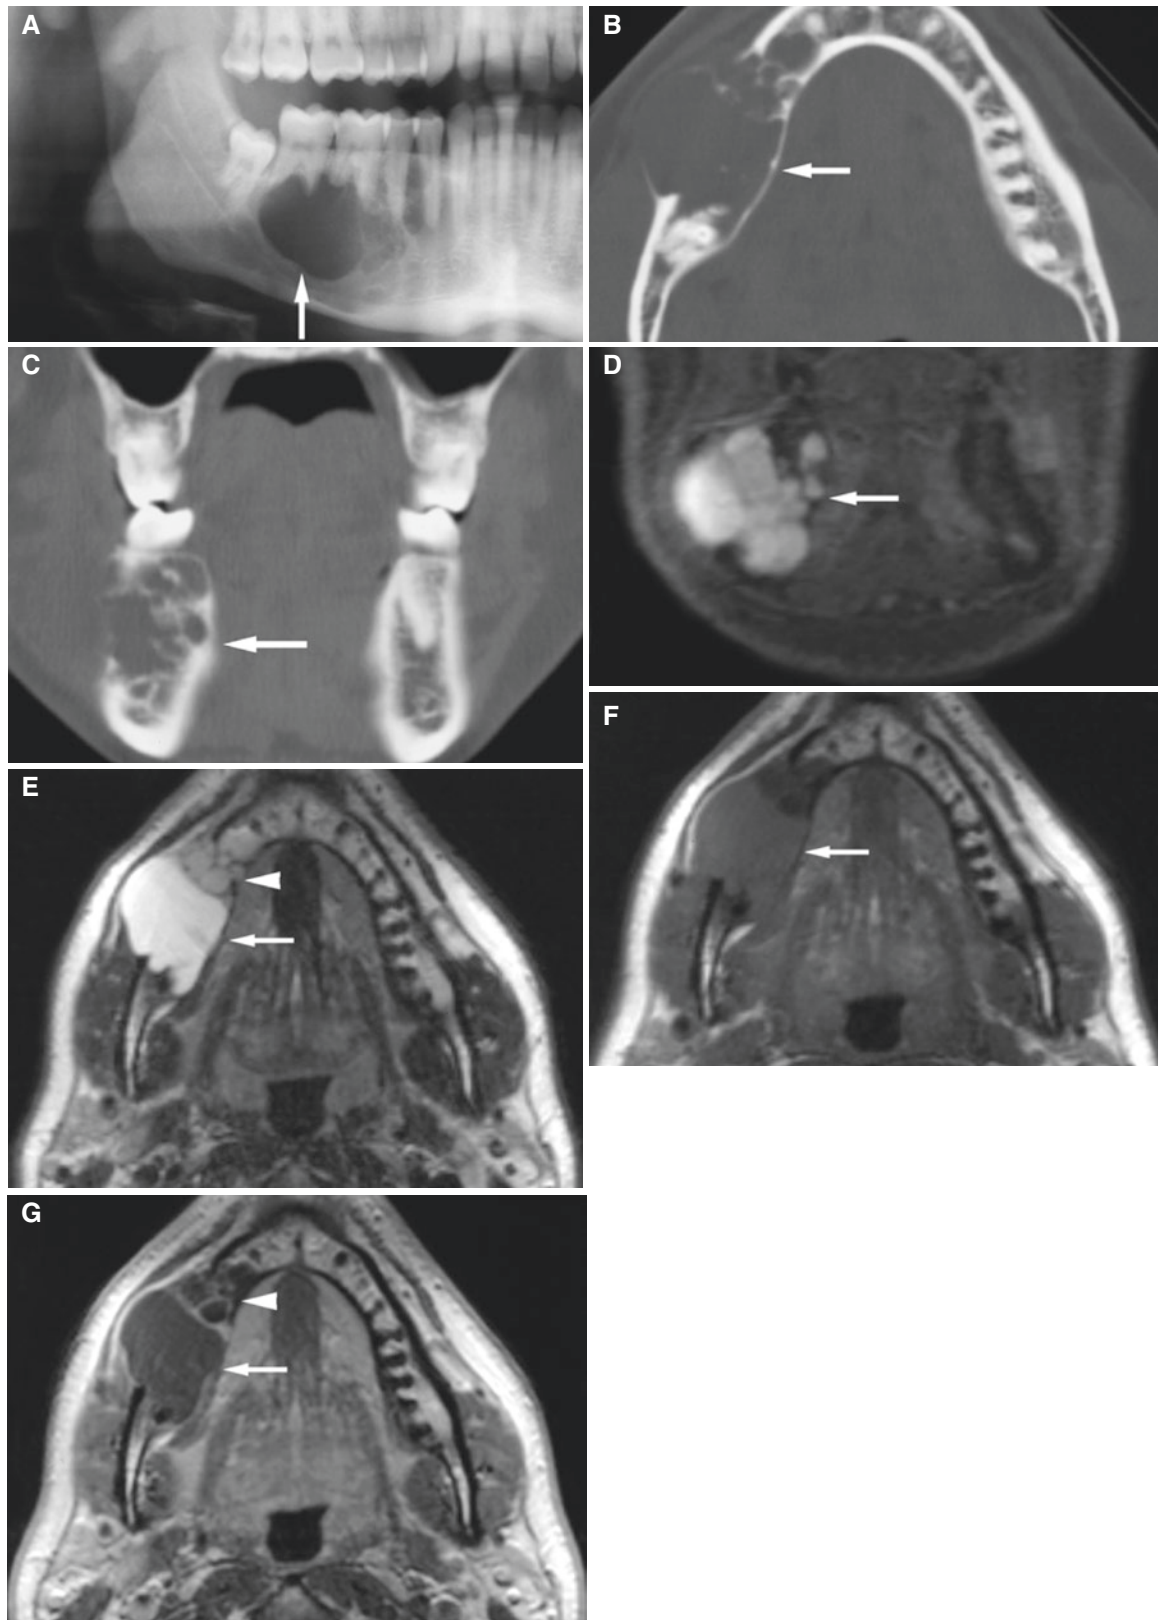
Ameloblastoma, unicystic, mandible; 22-year-old male with painless perimandibular swelling. (A) Panoramic view shows radiolucency and root resorption (*arrow*). (B) Axial CT image shows destroyed bone with expansion of buccal cortical bone, which is very thin and partially absent (*arrow*). (C) Coronal CT image shows multilocular appearance in anterior part without cortical outline buccally (*arrow*). (D) Coronal STIR MRI shows multilocular appearance and heterogeneous
